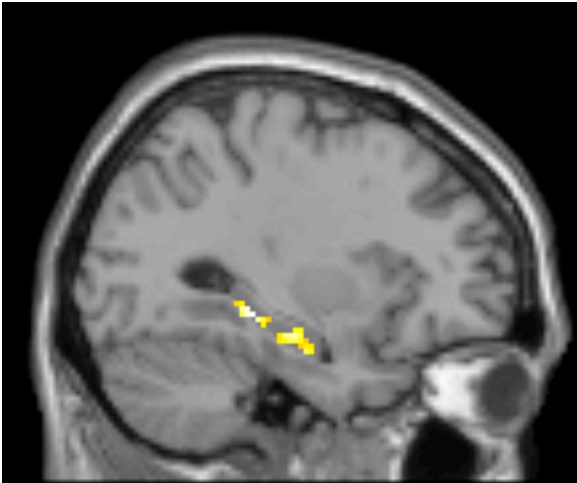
Statistical parametric map overlaid on a T1-weighted MR image showing the two significant clusters of negative associations between [¹¹C]SB207145 BP_{ND} and RAVLT immediate recall in left hippocampus.
